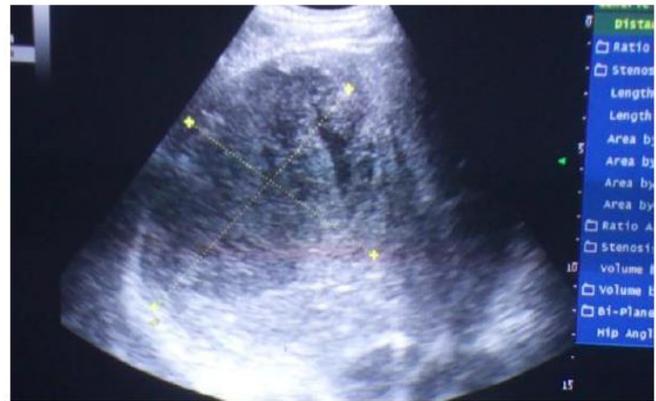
Ultrasound picture showing huge abscess in the right liver lobe
